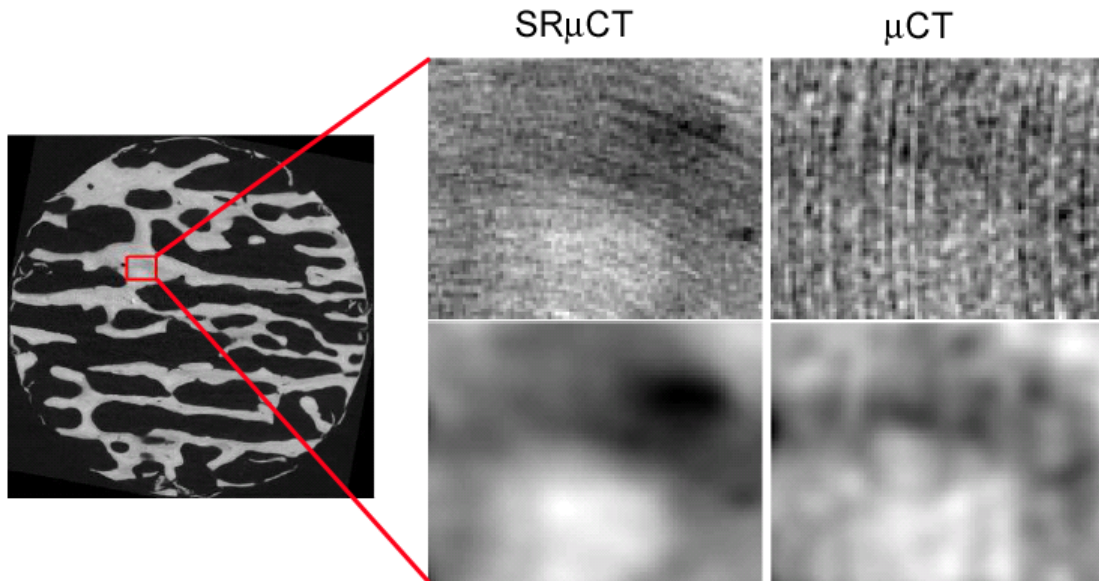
Example image where the region within the box is examined in greater detail Top left: part of SR image, top right: same part of CT image. Bottom left: SR image smoothed with a Gaussian ($\sigma = 2$), bottom right: CT image smoothed the same way. Note how after smoothing similar patterns can be visualized in both images.
